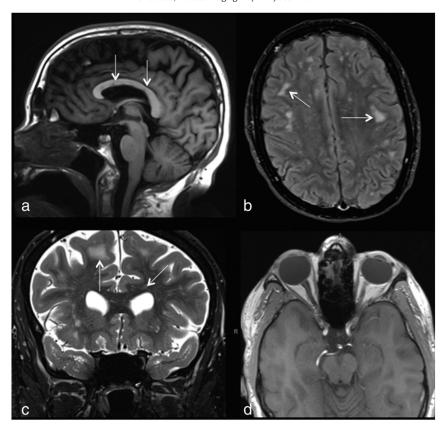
Sagittal T1-weighted (a), axial FLAIR (b), and coronal T2-weighted (c) magnetic resonance images of the brain demonstrate multiple foci of T1 and T2 prolongation within the subcortical white matter and corpus callosum (arrows). There is sparing of the subcortical U-fibers. No significant contrast enhancement is seen on the axial T1-weighted postgadolinium image (d).
